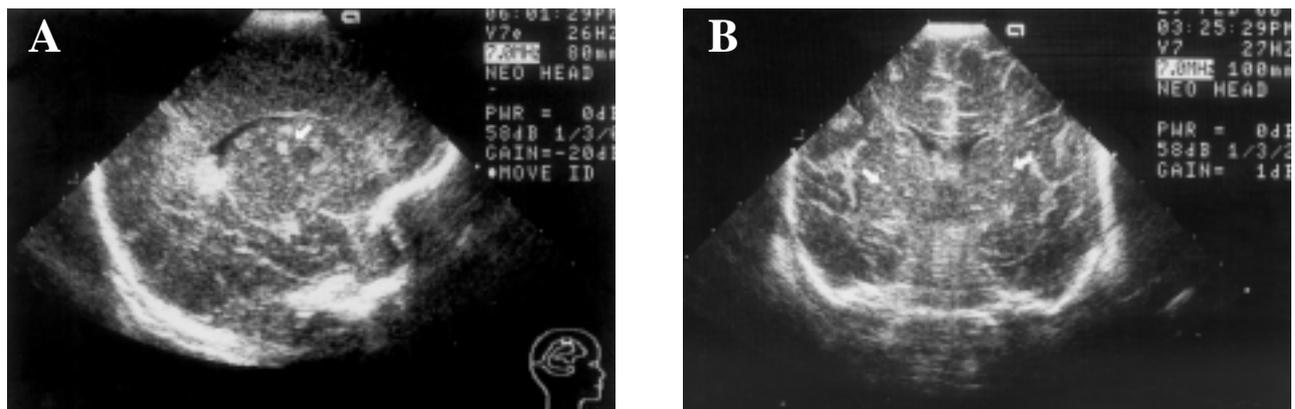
Parasagittal (A) and coronal (B) cranial ultrasound views performed on the 25th day of life. Arrows indicate multiple hyperechoic microabscesses scattered in the brain parenchyma, including the bilateral basal ganglia and periventricular white matter.
